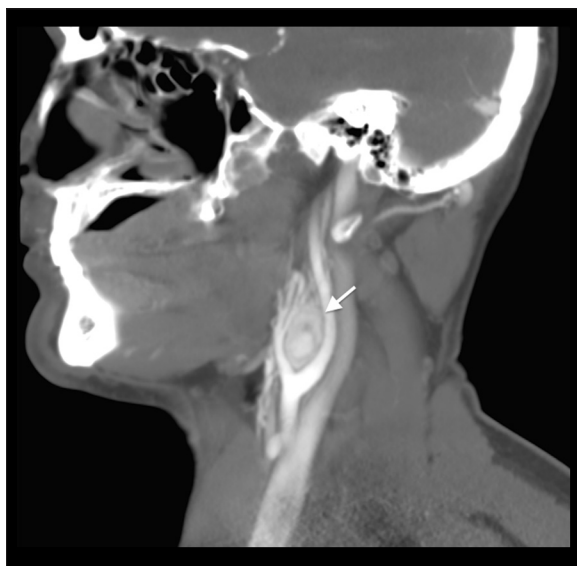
Carotid paraganglioma in a 32-year-old man with *SDHD* mutation. Contrast-enhanced CT, sagittal view, MIP reconstruction shows an intensely-enhancing mass in the left carotid bifurcation (arrow).
